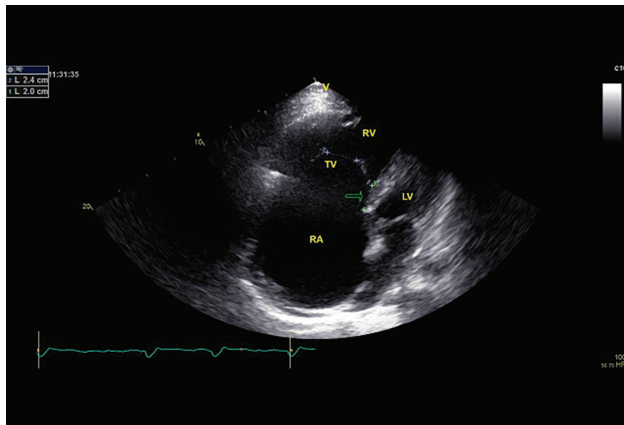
Apical four chamber view (modified view of the right ventricle), dilated right ventricle with apical displacement of the functional tricuspid annulus (arrow); failure of tricuspid leaflet coaptation.
